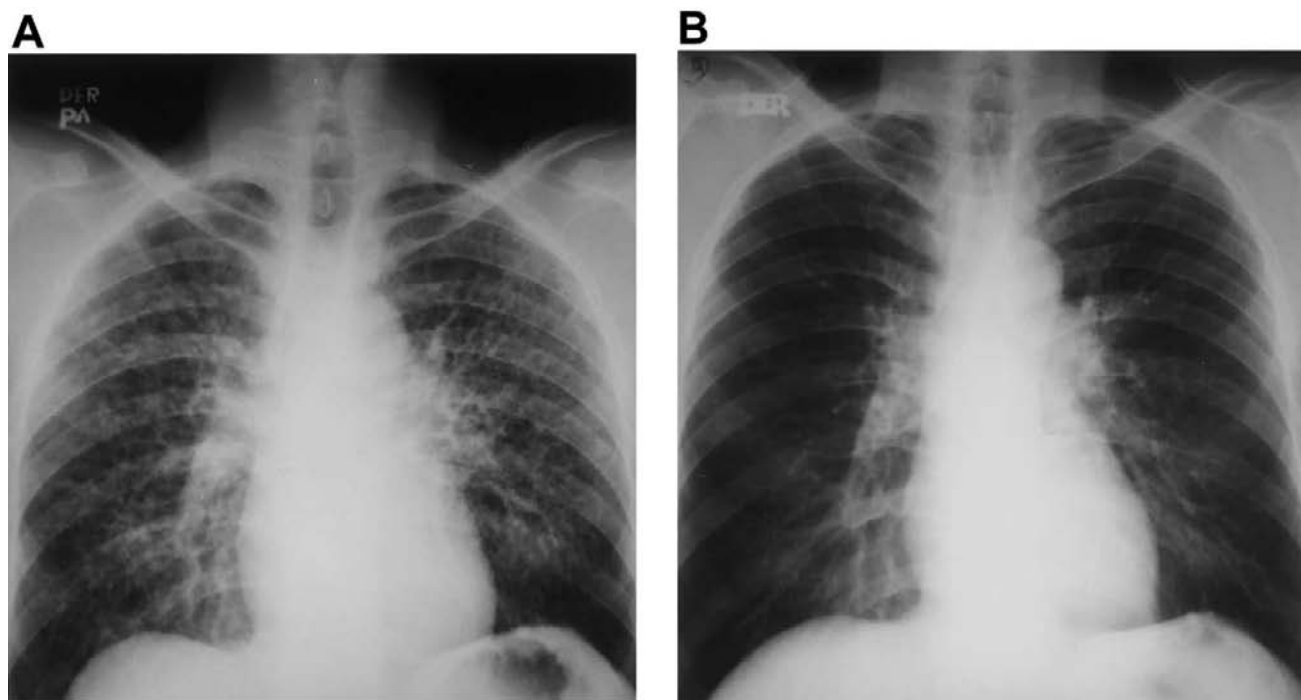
A, Chest radiograph at diagnosis showing severe interstitial infiltrates in a 45-year-old patient with paracoccidioidomycosis. B, Radiograph for the same patient at the end of the posttherapy follow-up period (12 months) showing clearing of interstitial lesions with no fibrosis in previously involved fields.
